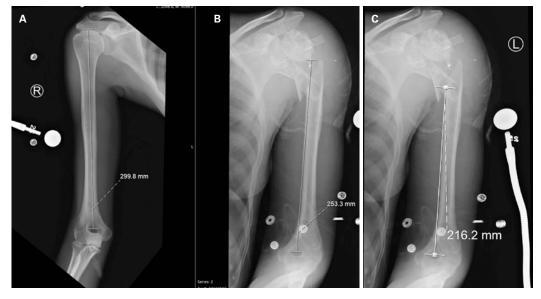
Humerus x-ray measurements. (A) Contralateral right humerus measurement with marker ball; (B) Left comminuted proximal humerus fracture with lateral measurement; (C) Left comminuted proximal humerus fracture with medial measurement
